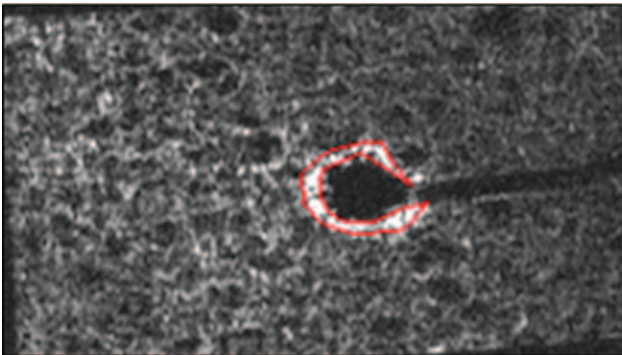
Signal intensity changes around the end of the endotracheal tube in the sponge in Figure 1 in a single slice on MR imaging following aerosol administration for 20 min. The red outline marks the region of interest.
